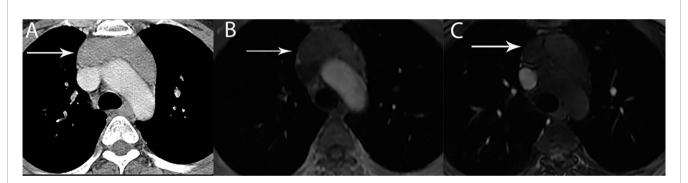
42 year old woman with Grave's disease and lymphoid thymic hyperplasia. (A) Contrast-enhanced CT shows mass-like thymic enlargement (arrow). With such an appearance, thymic hyperplasia, a thymic epithelial neoplasm or lymphoma involvement of the thymus cannot be distinguished one from another. (B, C) MRI with in and out of phase imaging shows drop in signal intensity consistent with thymic hyperplasia (arrow), obviating the need for further investigation or biopsy.
